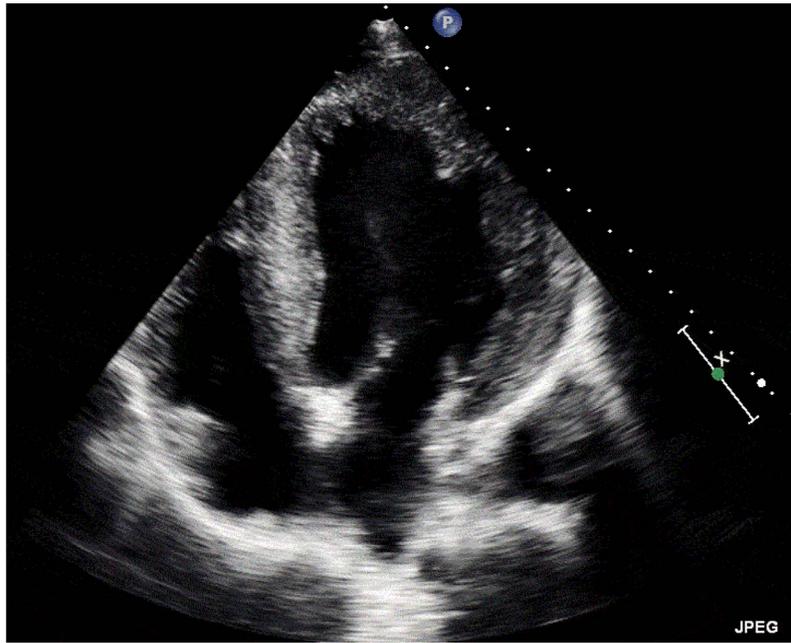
Apical 4-chamber (A4C) with depressed left ventricular (LV) function⁵.
